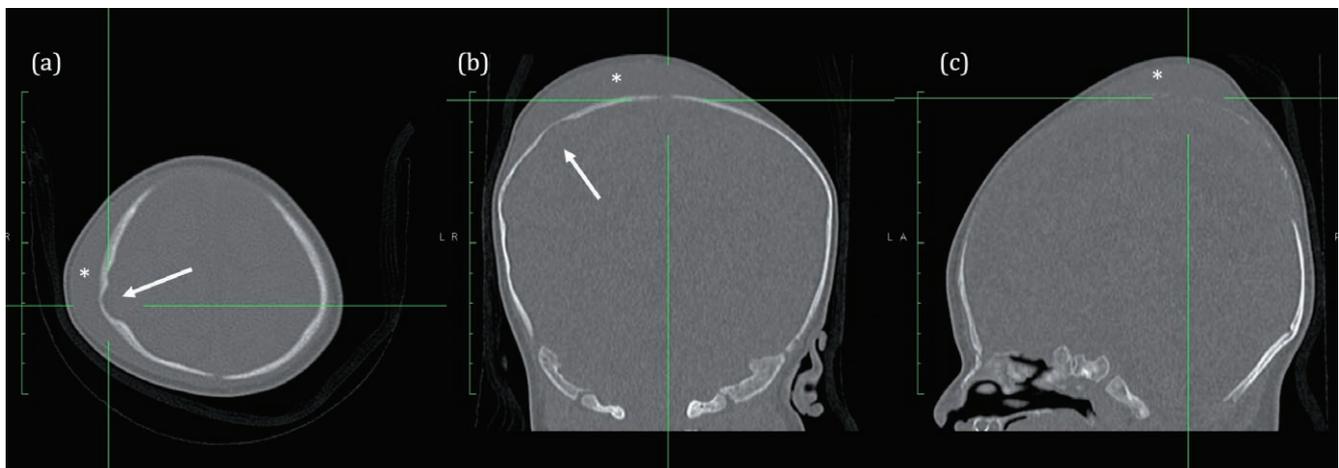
CT scan with (a) axial, (b) coronal and (c) sagittal reconstruction of the skull. The subaponeurotic fluid collection (*) is well appreciated. The associated localised skull thinning and mild protrusion (white arrow) can be seen underneath the swelling. Continuity is preserved with no periosteal reaction is seen.
